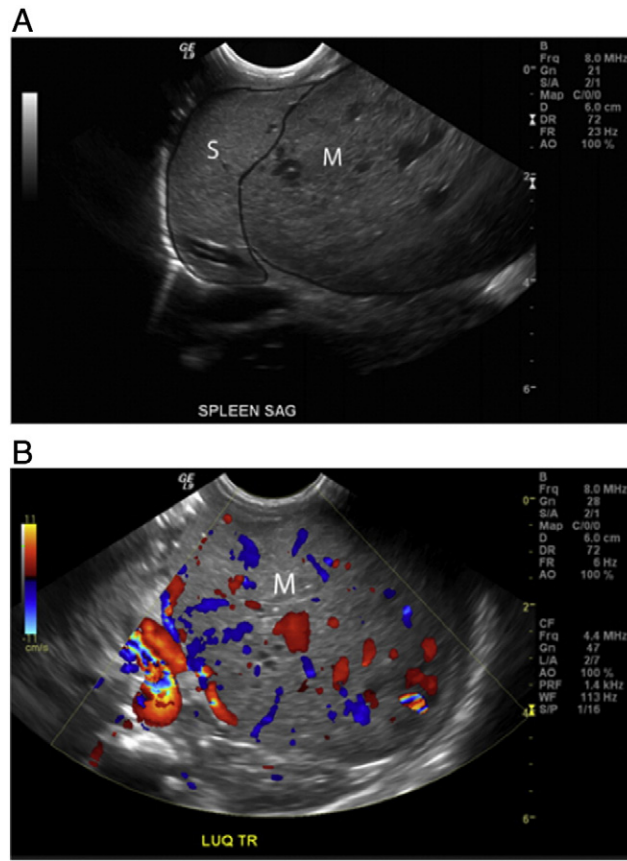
A) Grayscale sonographic image of the abdomen shows the lateral posterior border of the mass (M) adjacent to and inseparable from the spleen (S). Structure has been outlined for clarity. Because the spleen forms a “claw sign” with the mass and no tissue plane was seen between the mass and the spleen, it was suspected that the mass was splenic in origin. The mass demonstrates variable echogenicity with hypochoic serpinginous areas that could be areas of necrosis or large vascular channels. B) Color Doppler image of the mass (M) showing that the hypochoic serpinginous regions were mostly vascular and that the majority of the mass is vascularized.
